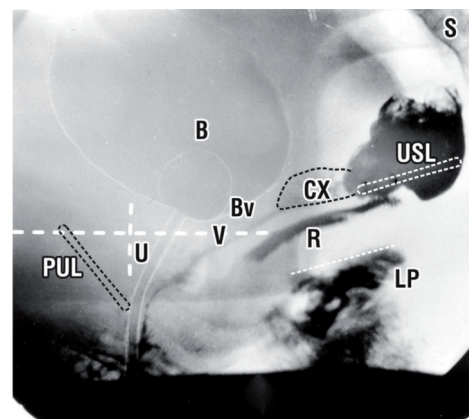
Resting x-ray. The vagina ‘V’, rectum ‘R’, urethra ‘U’ are stretched backwards by slow-twitch muscle fibres. The gentle downward displacement of the upper border of levator plate (LP) (broken lines) is by the slow-twitch muscle fibres of the conjoint longitudinal muscle of the anus (LMA).
